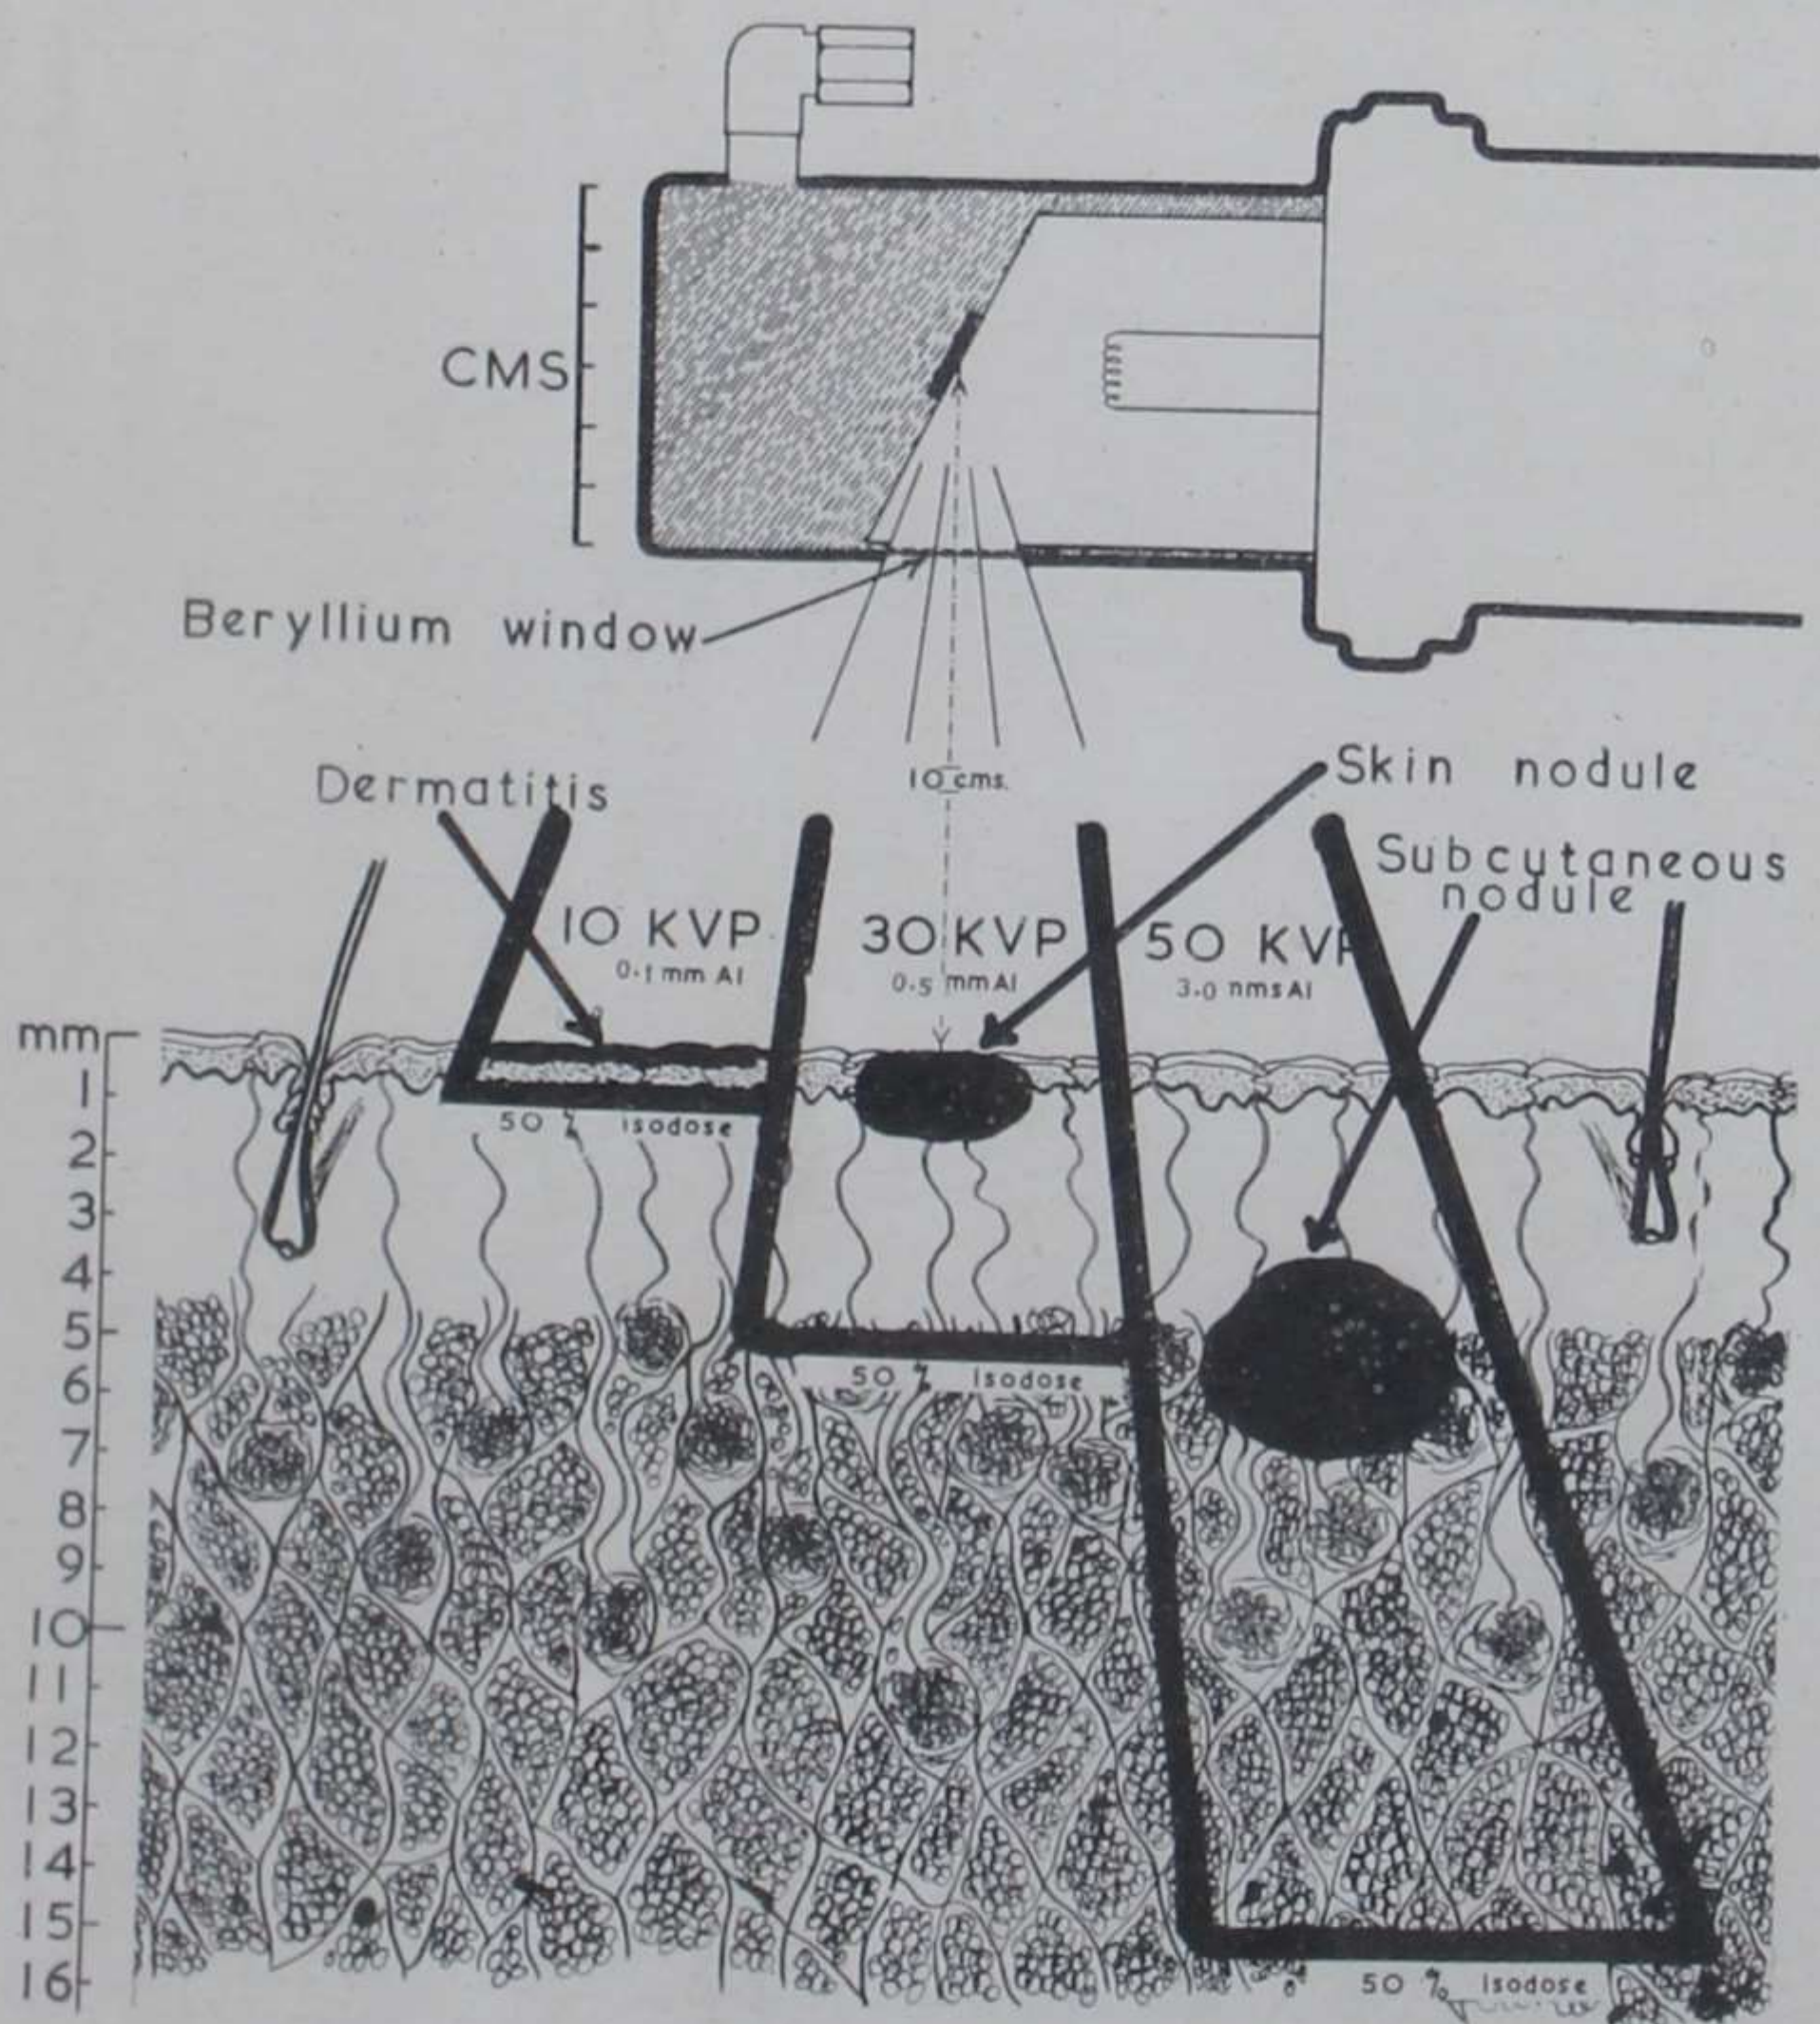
Three examples of treatment of breast conditions with low-voltage beryllium-window X-ray tubes, showing the wide range provided by the machine.
